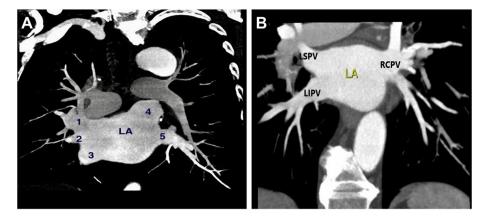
(A):Posteroanterior projection of cardiac CT showing three left PVs and two right PVs. Labels: LA: Left atrium. 1: Left superior PV. 2: Left middle PV. 3: Left inferior PV. 4: Right superior PV. 5: Right inferior PV. (B): Posteroanterior projection of cardiac CT showing two left PVs and a single right common PV. Labels: LA: Left atrium. LSPV: Left superior pulmonary vein. LIPV: Left inferior pulmonary vein.
